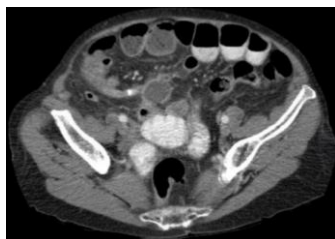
Computed tomography scan of abdomen and pelvis with intravenous and oral contrast revealed a mildly dilated appendix, measuring 7.5 mm in diameter, and mild wall thickening consistent with acute distended appendicitis
